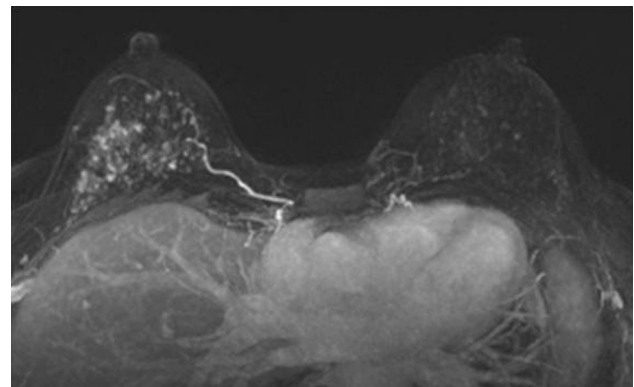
Axial contrast-enhanced T1-weighted fat-suppressed subtraction MIP MR image demonstrating asymmetric BPE in a patient with history of breast conservation surgery status post radiation therapy
